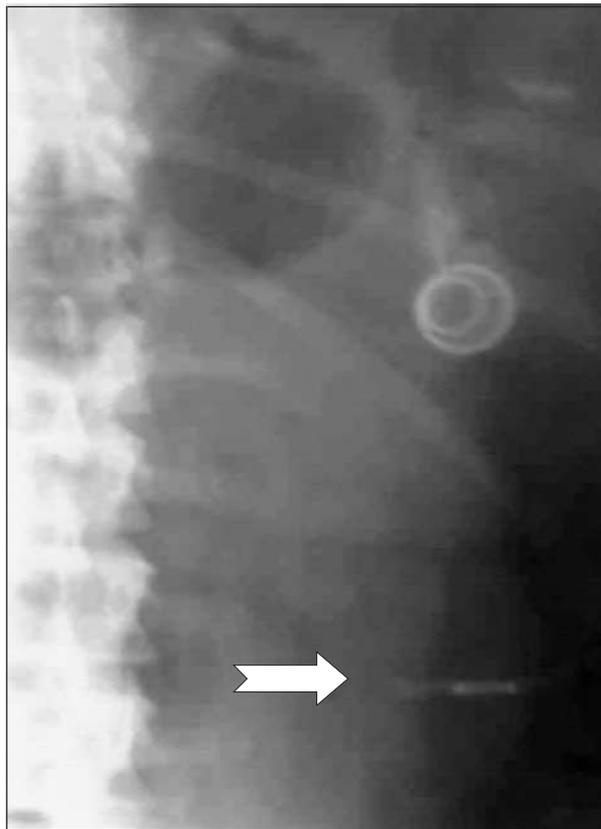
Intraperitoneal tube disconnection (arrow) (radiograph).
